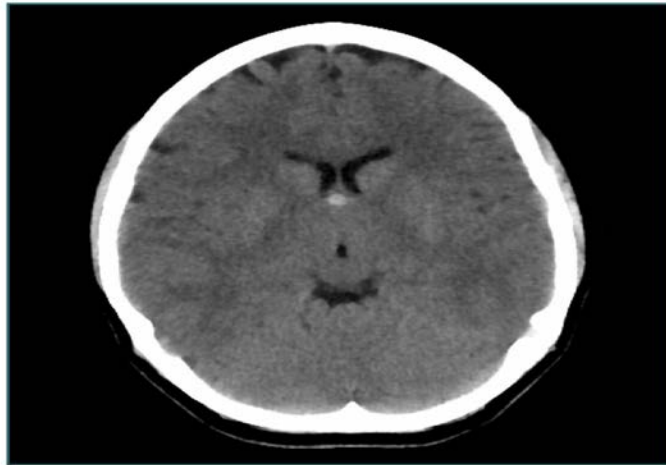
Image marked as D shows the axial section of a CT.
